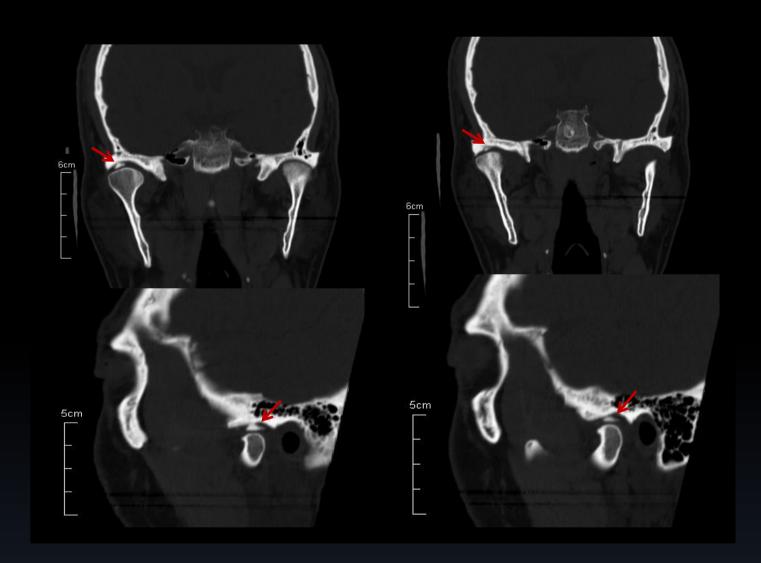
CT coronal and sagittal view showed a hyperdense image located between the right side condylar head and mandibular fossa. Irregularities on the surface of the mandibular fossa was also noted. Hypothesis of the hyperdense object as a fragment originated from the roof of mandibular fossa was suggested.
